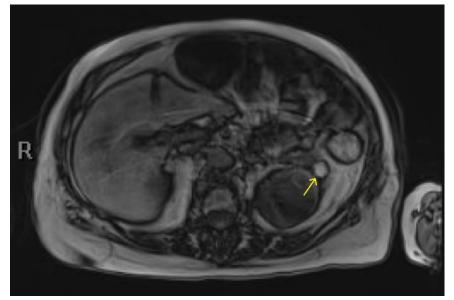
MRI Abdomen with/without contrast (1.5cm tumor noted in distal pancreas)
